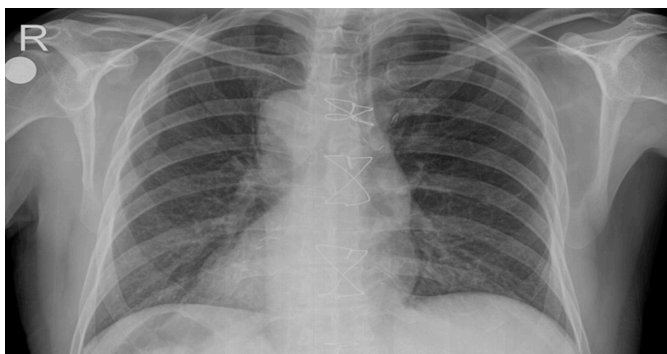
Chest X-Ray shows dextrocardia of patient with situs inversus totalis.
